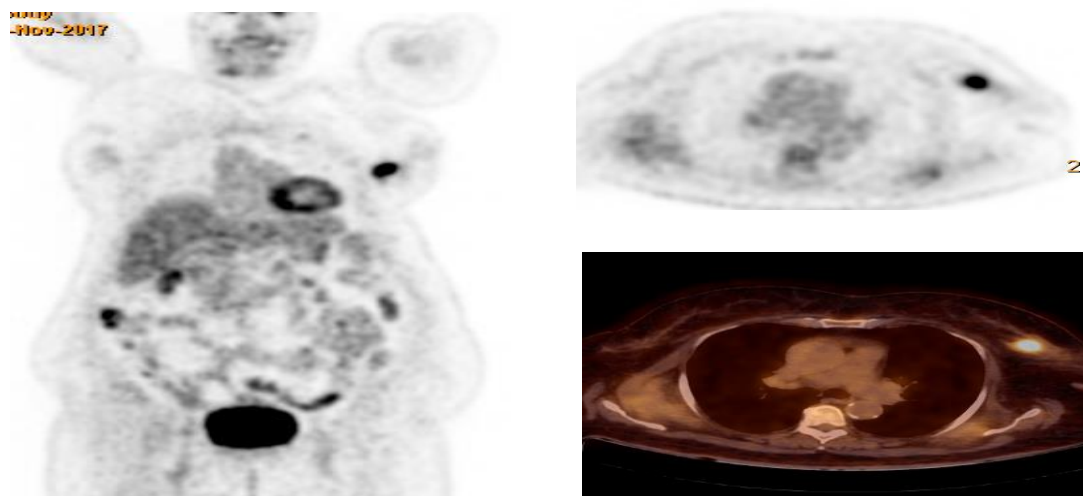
57 year old female patient with left breast UOQ unifocal mass lesion. Staging: T2N0M0 Stage 2. Pathologically proven IDC grade III, ER positive, PR negative, HER2/neu negative and Ki-67 proliferation index (5%). The PET/CT derived metabolic parameters (SUVmax11.7, SUVmean 7.09, MTV7, TLG47.19, TLR4.11 and size 3.4 cm).
